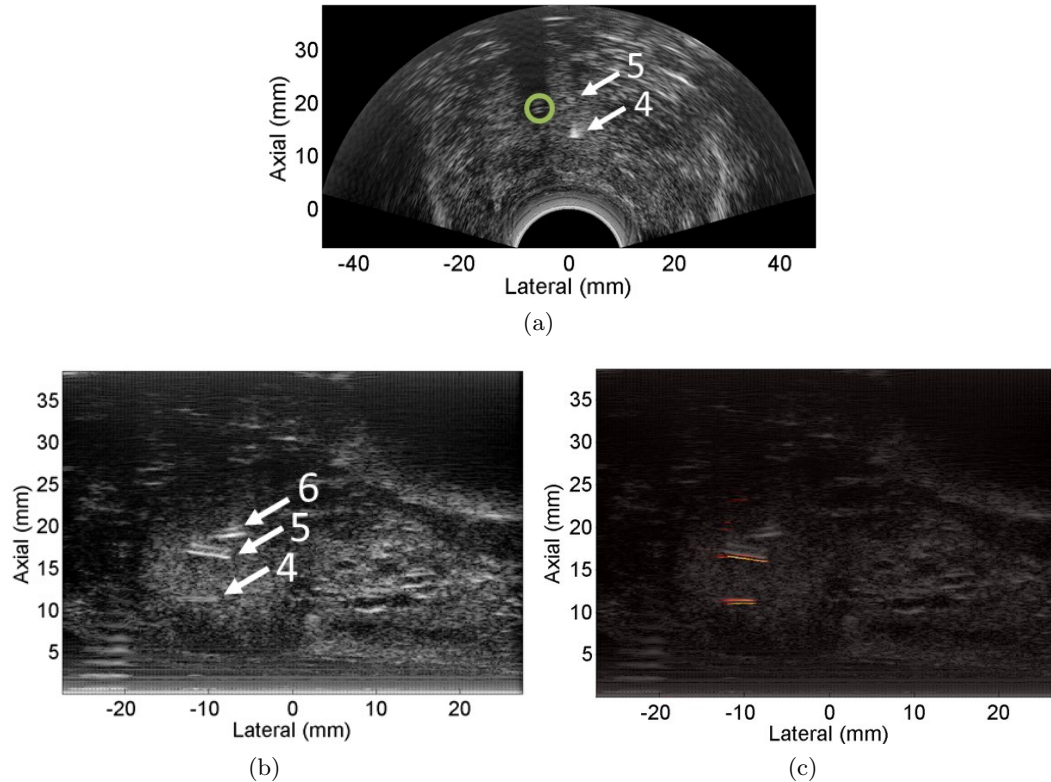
Ultrasound images of brachytherapy seeds in the second prostate, acquired with the (a) curvilinear and (b) linear arrays. (c) Photoacoustic image acquired with light directed toward seed #5 and shown with 8 dB dynamic range.
